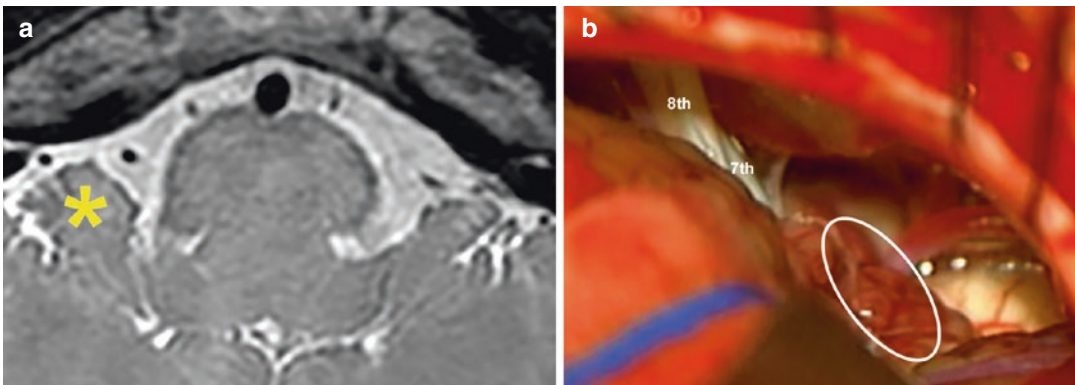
Flocculus blocking the visualization of the neurovascular compression site. (a) Preoperative MRI showed a larger flocculus on the right (asterisk) than left side. (b) While approaching the neurovascular compression site, the flocculus blocked the visualization of the site and further retraction of the cerebellum including flocculus was
